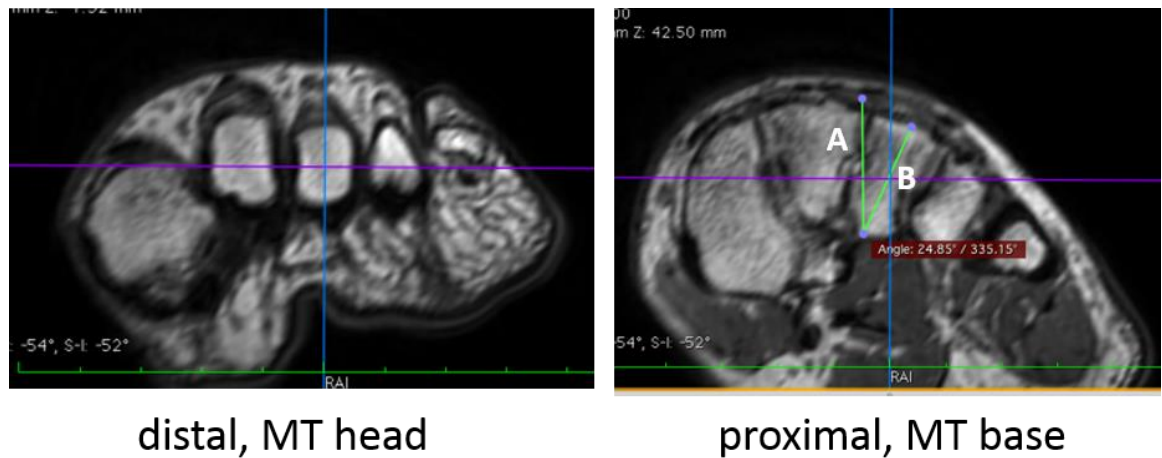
Measurement of the base-diaphysis angle on an MRI. The base-diaphysis angle is measured as the angle enclosed between the green lines A and C. The purple and orange lines mark the location of the transverse and coronal view frames, respectively.
